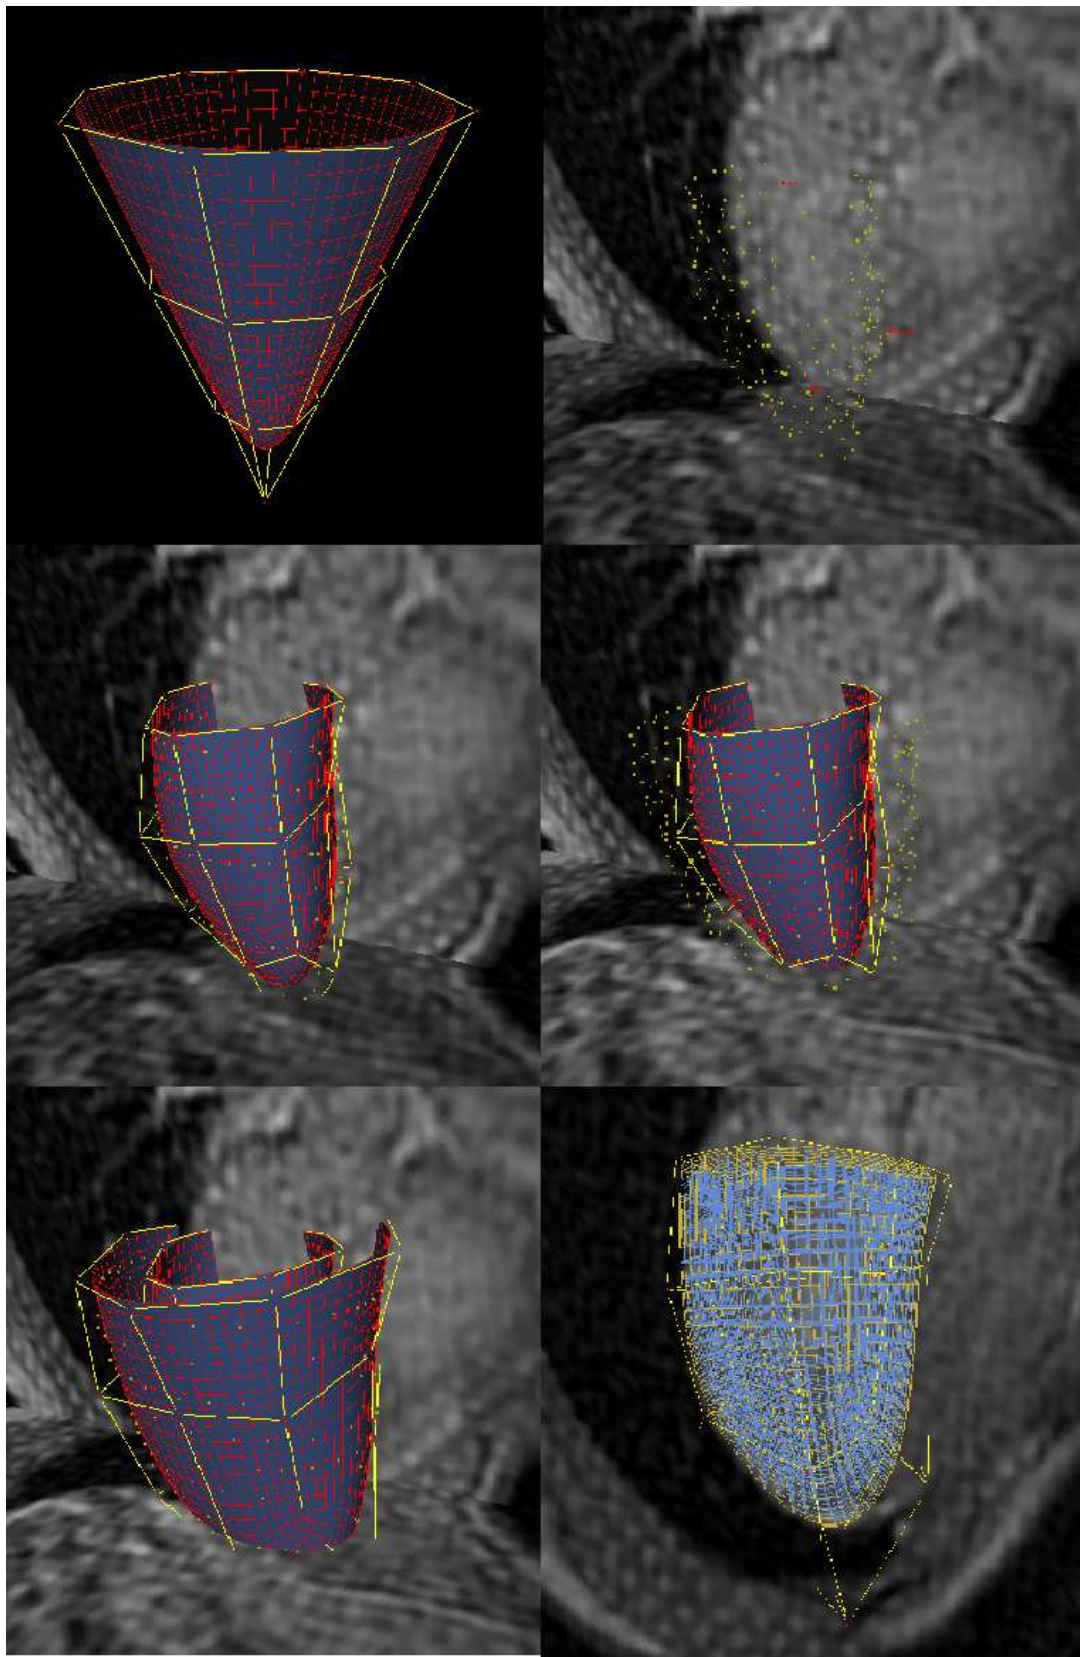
Left ventricle subdivision model from tagged MRI
